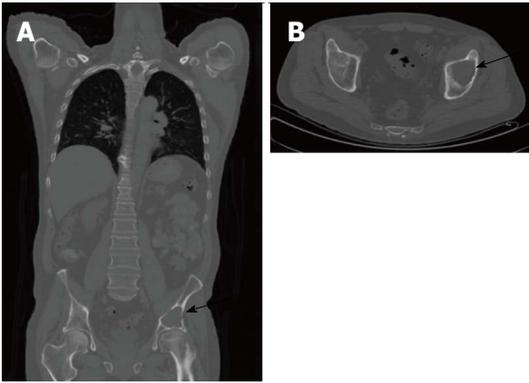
Computed tomography of an osseous myeloma lesion. Computed tomography in coronal (A) and transversal views (B) showing an osteolytic lesion in the left iliac bone (arrows) representing an osseous myeloma manifestation.
